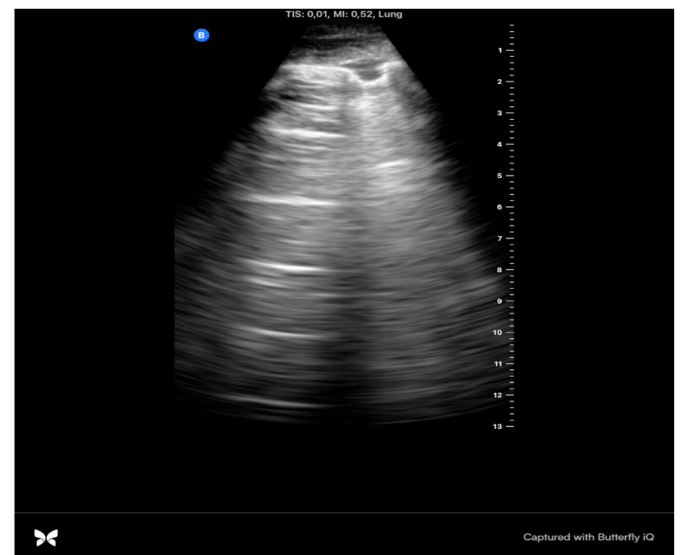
Lung ultrasound image obtained from the left upper lung zone demonstrating preserved A-lines with focal interruption by vertical hyperechoic B-line artifacts
